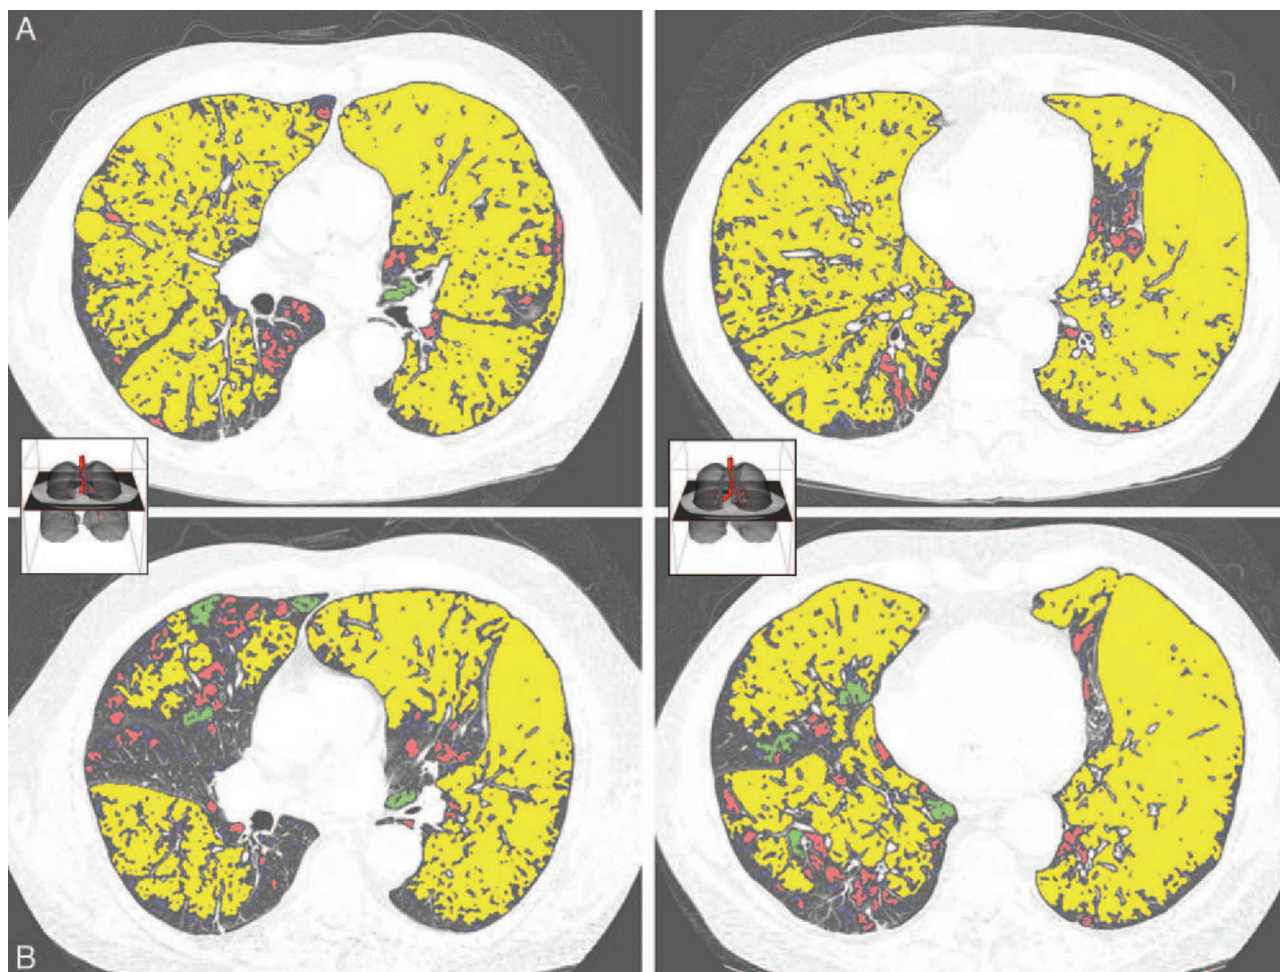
Color map of CT scan in inspiration (*top, A*) and expiration (*bottom, B*) at the same level of carina and lower lobes: clusters class 4 (yellow), class 3 (green), class 2 (red) and class 1 (blue). At the same anatomical level related to main bronchi and great vessels the lung parenchyma landmarks (like interlobar fissure) changed their position. Note the different change of fissure position for right and left lung and shift of the mediastinum corresponding to better expiration on the right than on the left side.
